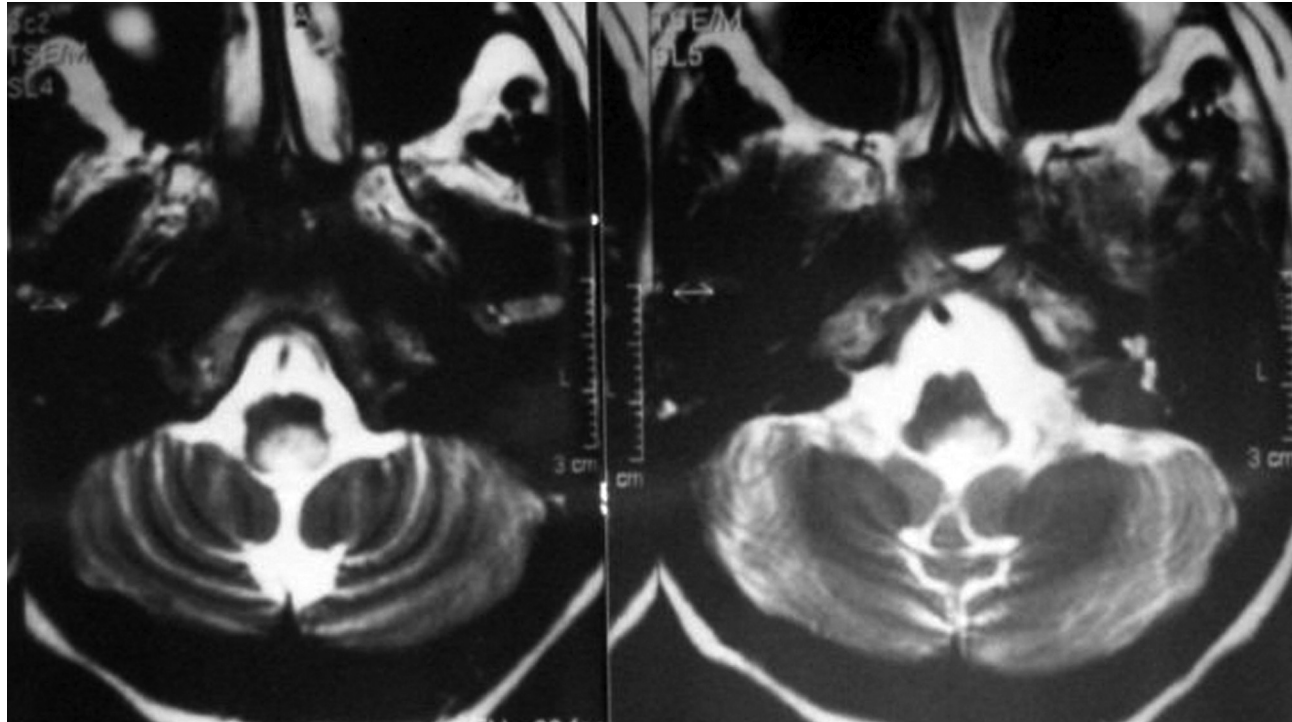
The T2-weighted axial magnetic resonance images show an area of hyperintensity in the medulla oblongata.
